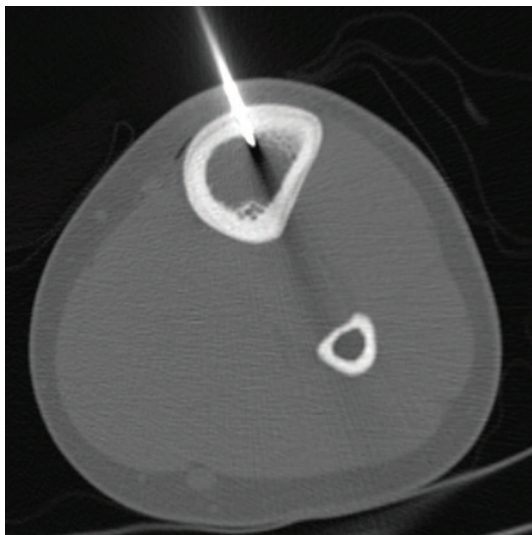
CT-guided biopsy of the left tibia.
